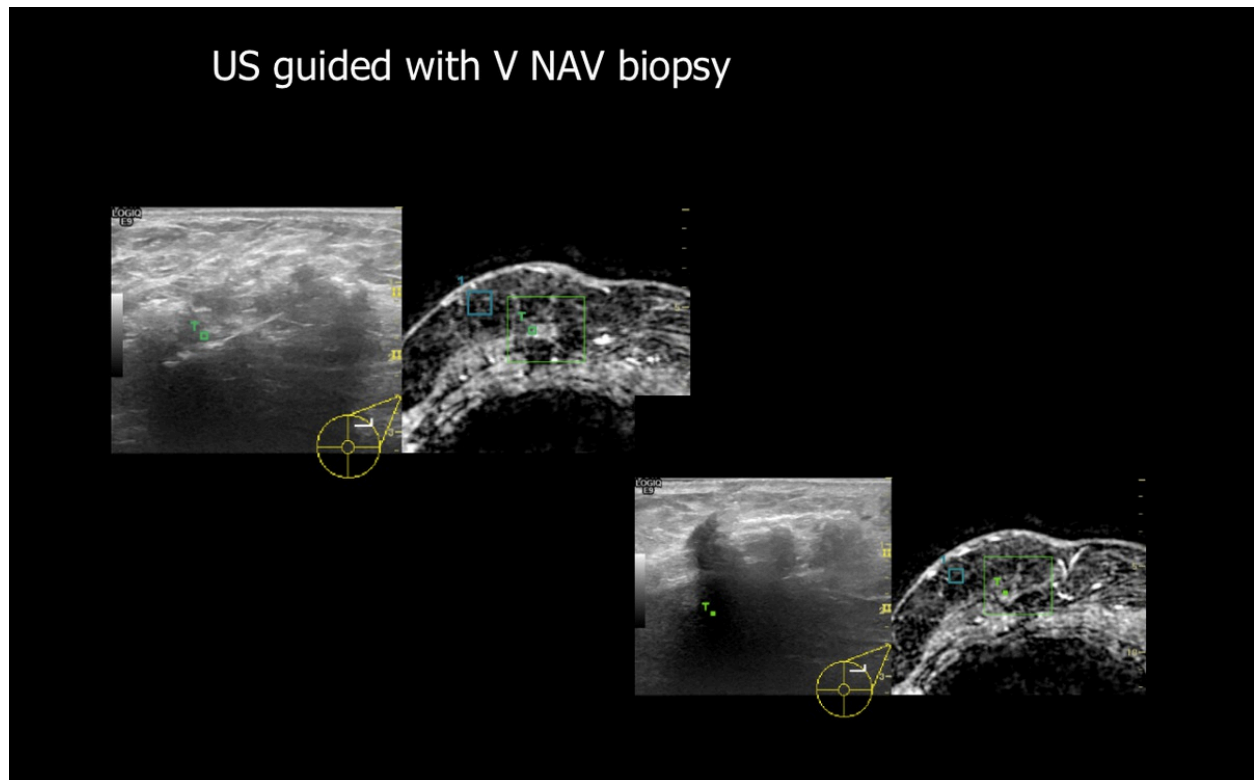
Two example of US guided biopsy using V Nav in which lesion is well-depicted in MR images ma a GPS marker (green dot) shows where the lesion in on the US corresponding image.
